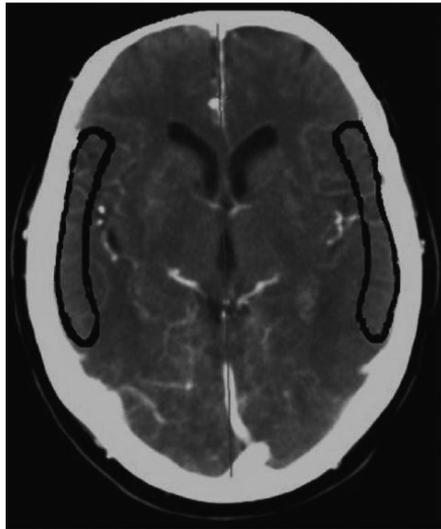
Manual outlining of middle cerebral artery territory on transverse CT sections, according to the maps of Damasio.<sup>20</sup>
